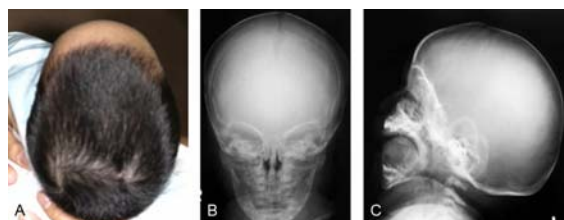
Patient with sagittal craniosynostosis (A) shows the scapho-cephalic head shape. Plain films of skull in frontal (B) and lateral (C) projections show premature synostosis of the sagittal suture with elongation of the calvarium in the occipital-frontal direction and decreased transverse axis of the calvarium
